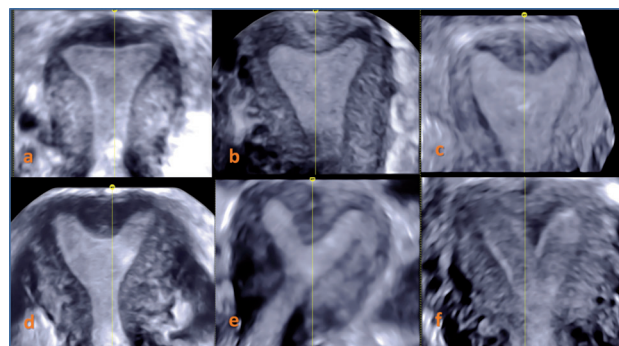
Three-dimensional ultrasound reconstructed coronal plane of minor congenital uterine malformations. a, b: normal – Class U0 uterus; c: dysmorphic uterus Class U1c – arcuate; d, e and f: partial septate uterus – Class U2a.
